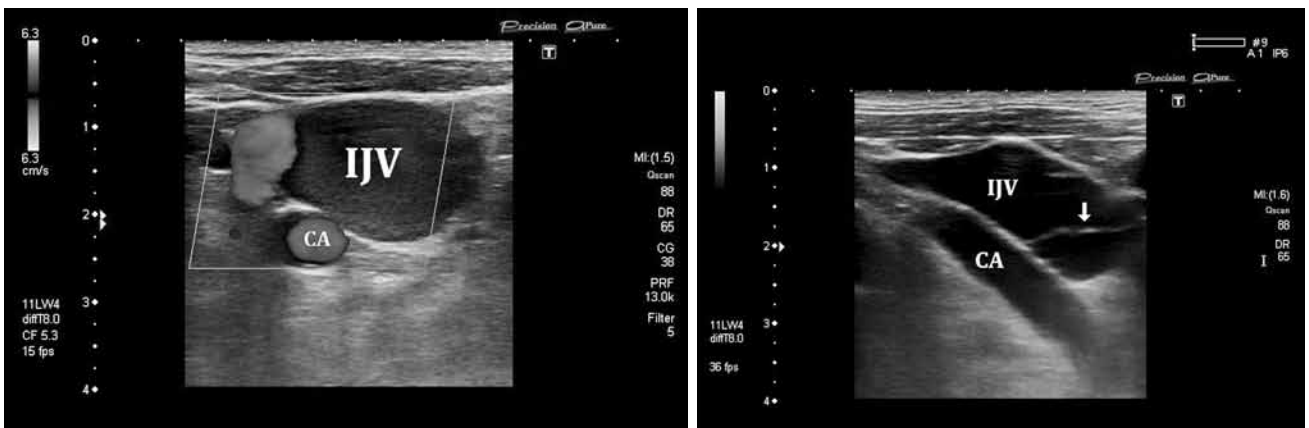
Transverse (upper) and longitudinal (bottom) color Doppler ultrasound images are showing internal jugular vein phlebectasia. Arrow at bottom image shows presence of vein valve at bulbous level.
